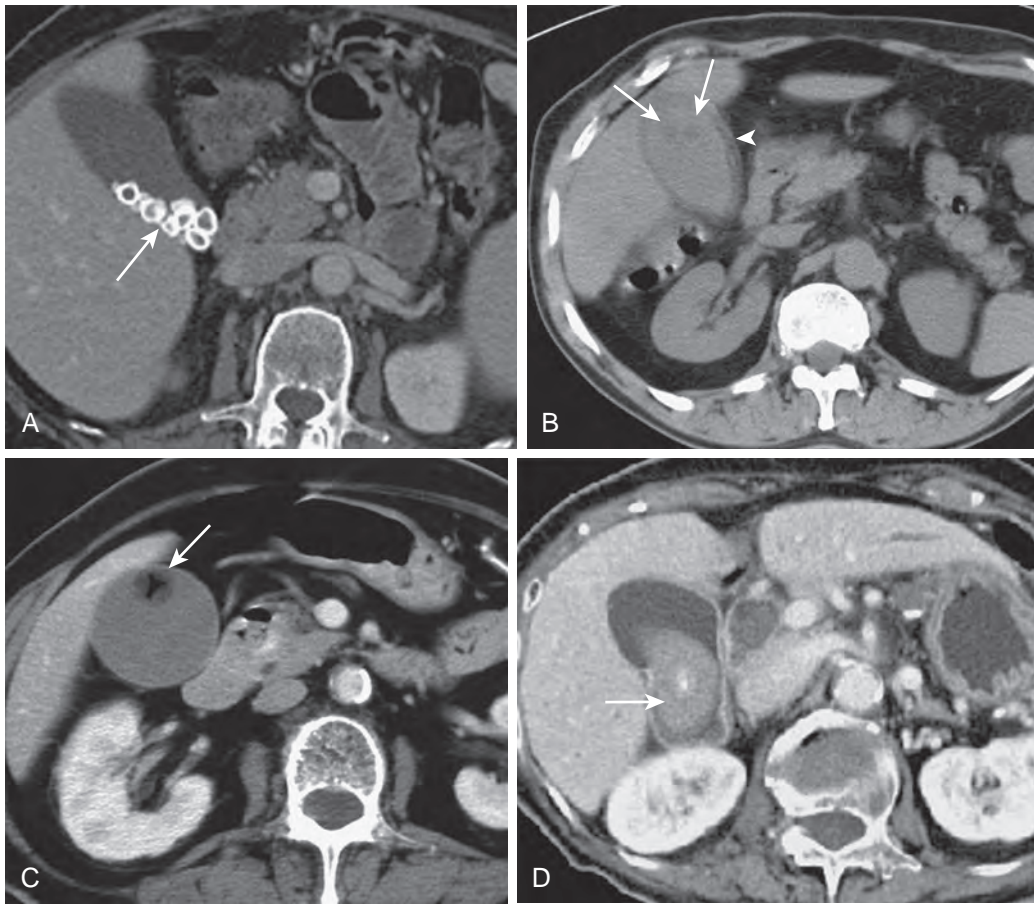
CT appearance of gallstones. A. Calcified stones depicted as calcified dependent densities in gallbladder lumen (arrow). B. Noncalcified stones may be visible if they are less dense than bile (arrows). This patient also had acute cholecystitis. Note thickened gallbladder wall (arrowhead). C. Mercedes-Benz sign. Gas-containing stone floating in bile (arrow). D. Pigment stone (arrow) is soft tissue density with only small central nidus of calcification.
